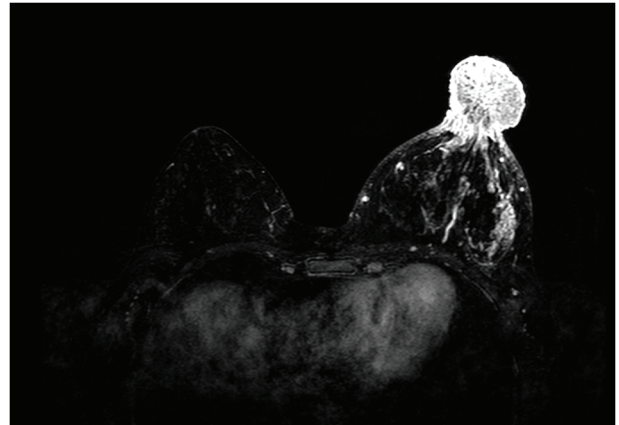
Magnetic resonance imaging of the breast showing an enlarged mass located on the left nipple.
